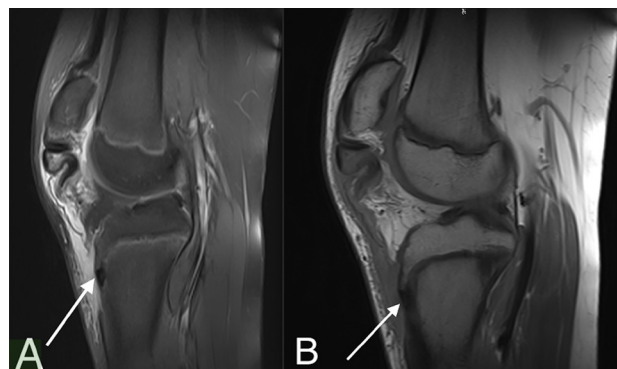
Preoperative (A) T2 weighted; (B) T1 weighted magnetic resonance images of the affected knee showing complete rupture of patellar tendon from the tibial tuberosity
